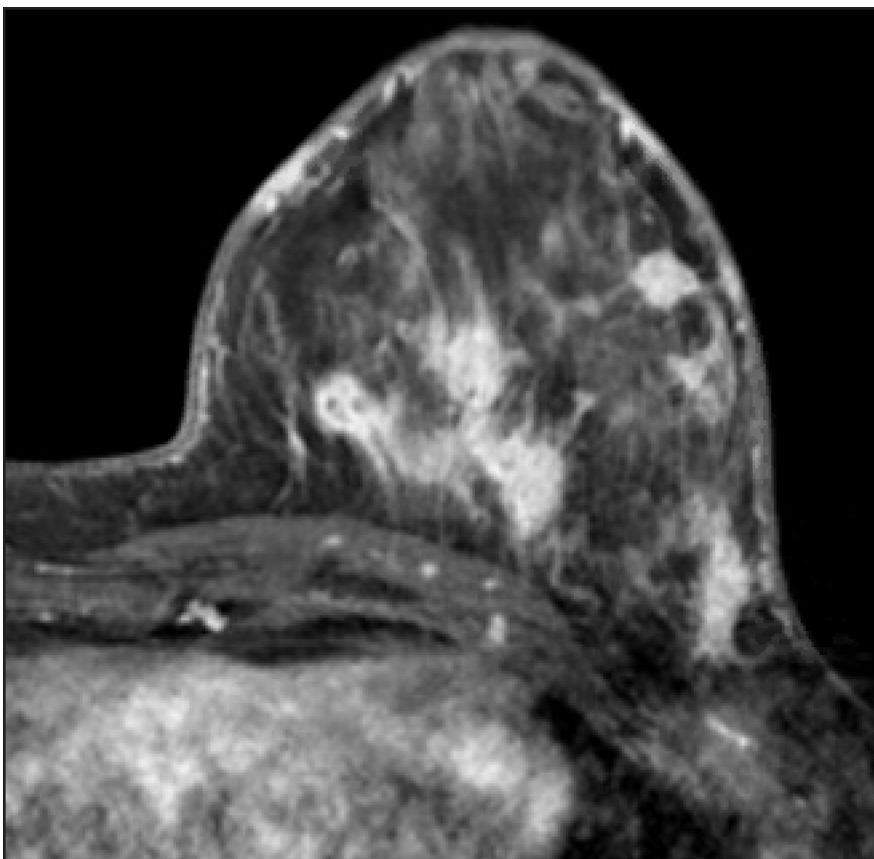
Axial T1-weighted fat-subtracted postcontrast MRI depicts the left breast at the level of the site of concern in the inferior breast. Multiple sites of nonmass enhancement are appreciated along with several distinct sites of skin enhancement.
